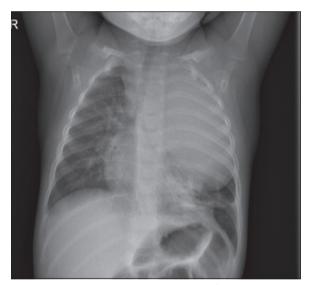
Chest x-ray. A mediastinal mass of approximately 13 cm in diameter is observed. It collapses and displaces the left lung to the contralateral side from the vertex.
